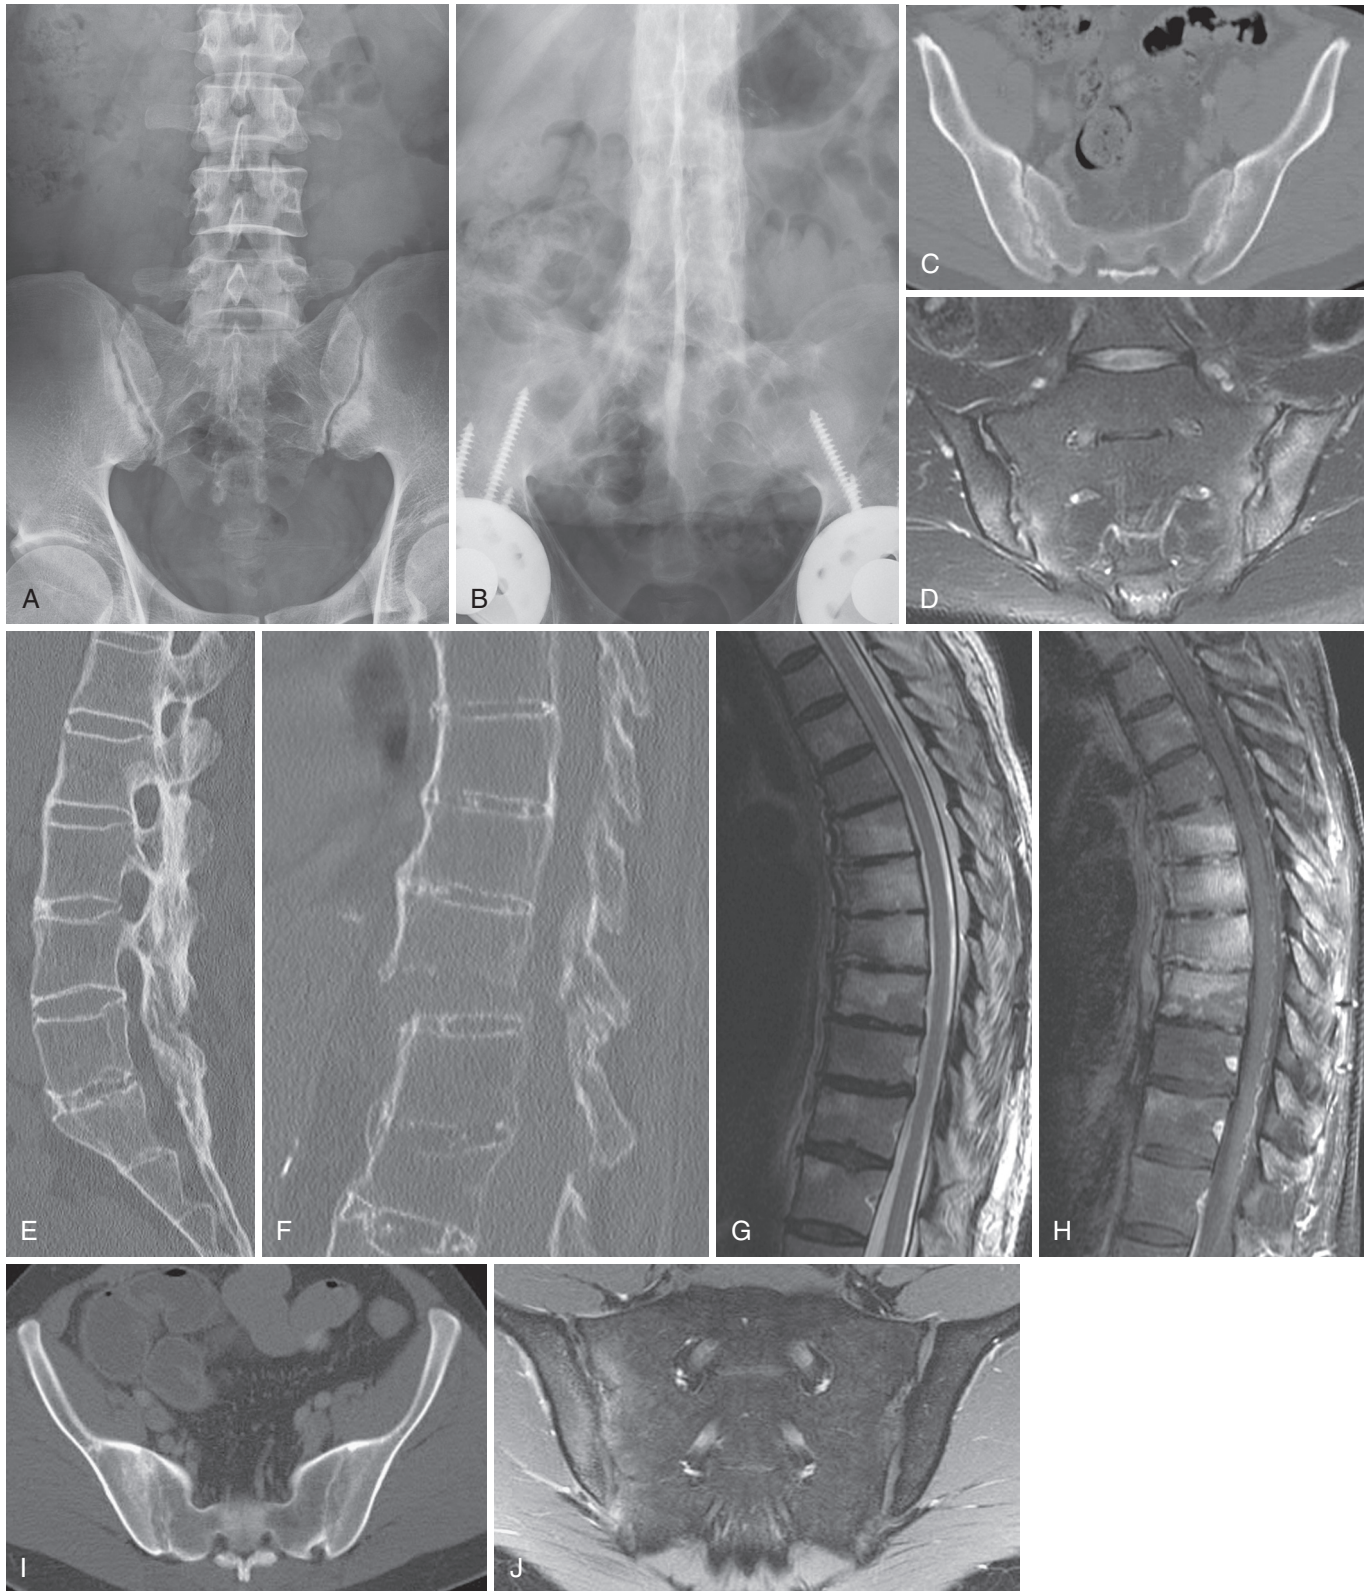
Spondyloarthropathy. Changes of sacroiliitis are detectable on radiographs (A) as irregularity, erosions, and sclerosis, dominant on the iliac side of the joint. In the end stage of ankylosing spondylitis (AS), the sacroiliac joints are fused and the sclerosis resolves (B); this radiograph also depicts the dagger sign, as the fused spinous processes make a continuous sclerotic structure in the midline. CT (C) is more sensitive in the detection of erosions and early sclerotic reaction in AS; this structural change may simply reflect prior disease. Only MRI can detect disease activity (D) as demonstrated by the T2 hyperintensity in and about both SI joints in this AS patient. The gracile vertical syndesmophytes bridging lumbar vertebrae and the fused posterior elements are well seen on CT (E); the spine in AS is rendered vulnerable to three-column unstable fractures with modest trauma (F). These situations deserve CT imaging. The spondyloarthropathy of inflammatory bowel disease may present as back pain (T2 sagittal [G] and enhanced T1 fat-saturated sagittal [H]) with evidence of multifocal inflammatory spondyloarthropathy. The differential diagnosis here is multilevel spondylodiscitis, especially Pott's disease (tuberculosis). Changes of sacroiliitis in inflammatory bowel disease (I) may be indistinguishable from AS. Asymmetric sacroiliitis (T1-enhanced, fat-saturated coronal MRI [J]) is typical of reactive spondylarthritis (formerly Reiter's syndrome).
